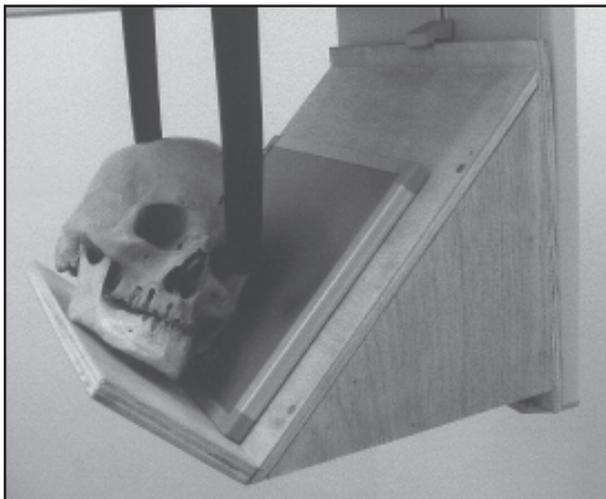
Skull placed on the inclined wooden plane adapted to the chassis holder of the teleradiography x-ray machine to make lateral oblique radiographs of the mandible for angle and body
